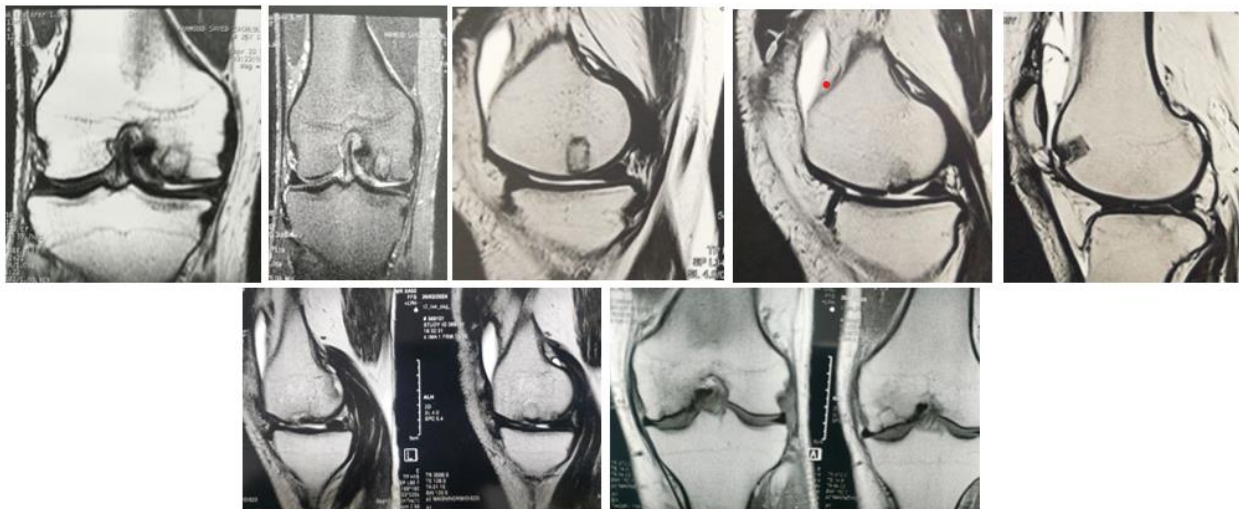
Post-operative follow up MRI of 2 cases
